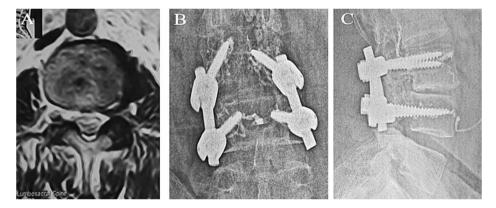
A 48-year-old female patient with degenerative spondylolisthesis with left L3-L4 foraminal stenosis and facet osteoarthropathy: (A) preoperative axial T2 MRI; (B) postoperative anteroposterior; (C) lateral plain radiographs showing minimal vascular and intraspinal (opposite L2-L3 disc space) cement leak that was asymptomatic.
